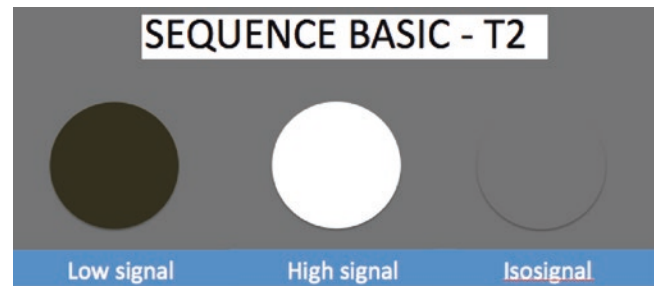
Various signal intensities in MRI. When the uterus is taken as a reference, the structures can have a hyperintense, hypointense, or isointense signal
